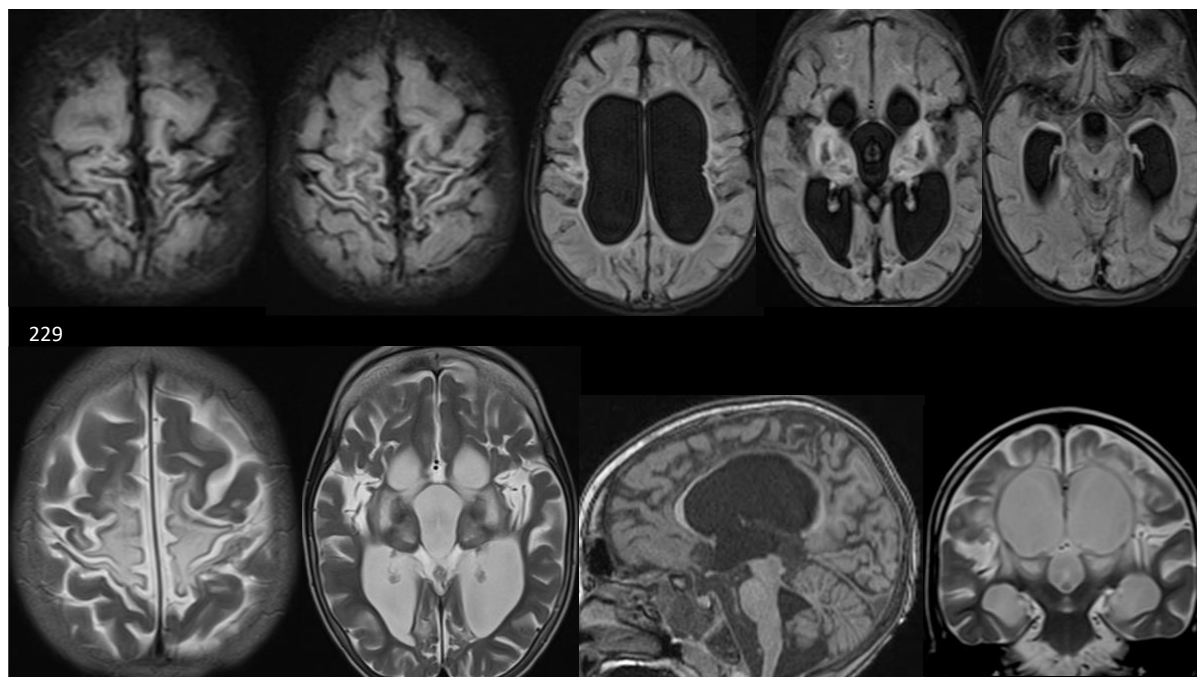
Collage of MRI images obtained for patient 229
